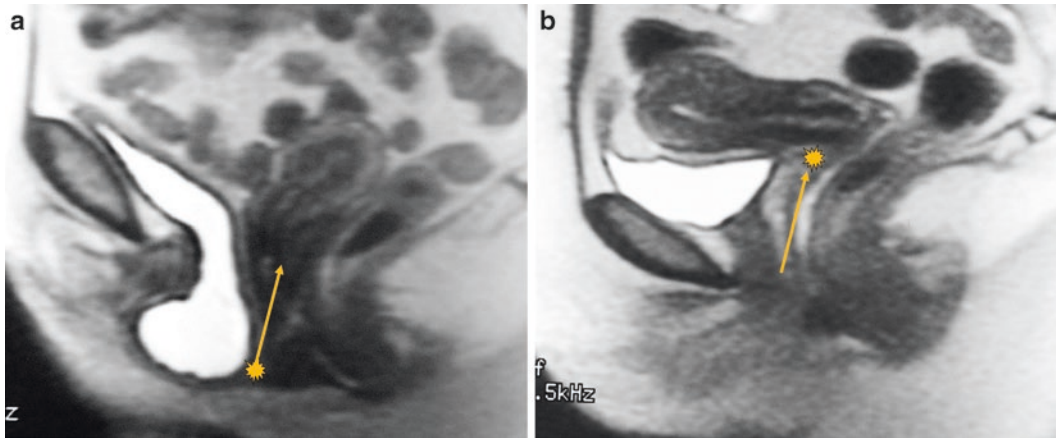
(a) Magnetic resonance image (MRI) of multi-compartment ureterovaginal prolapse, sagittal view. (b) MRI of normal anatomic position. Star and arrow represent theoretical focal point and vector of suspension to
